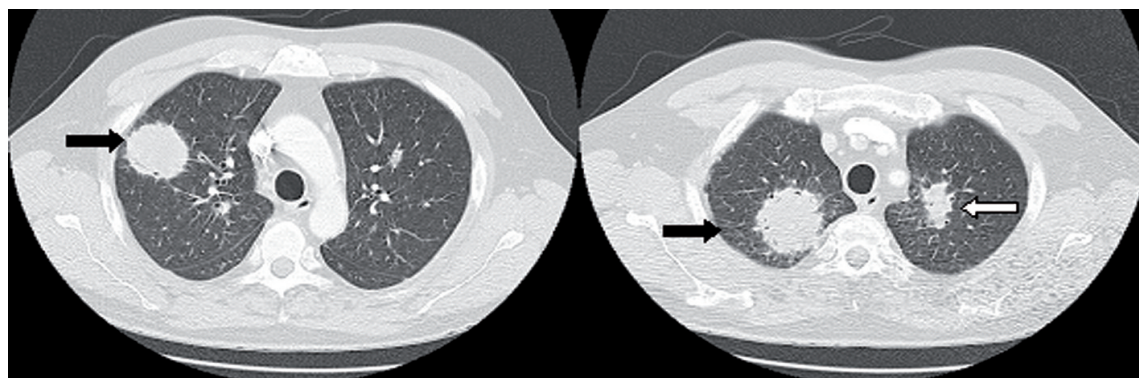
(a). Thoracic CT scan indicating pulmonary infiltrates.
